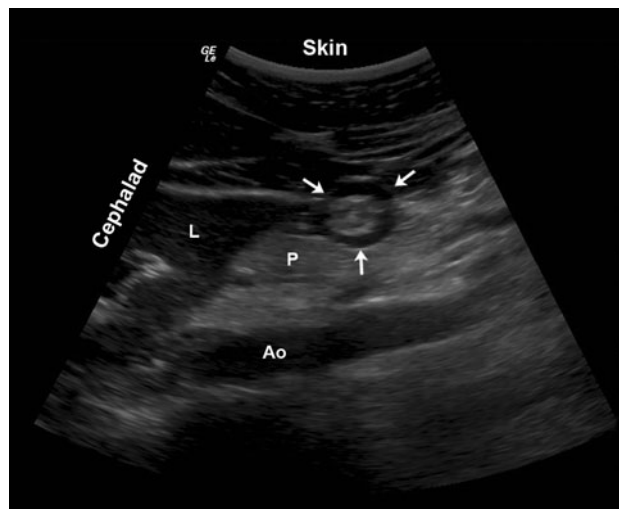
Sagittal sonogram of the empty antrum resembling a “bull’s eye” target (arrowheads). L = liver; P = pancreas; Ao = aorta
